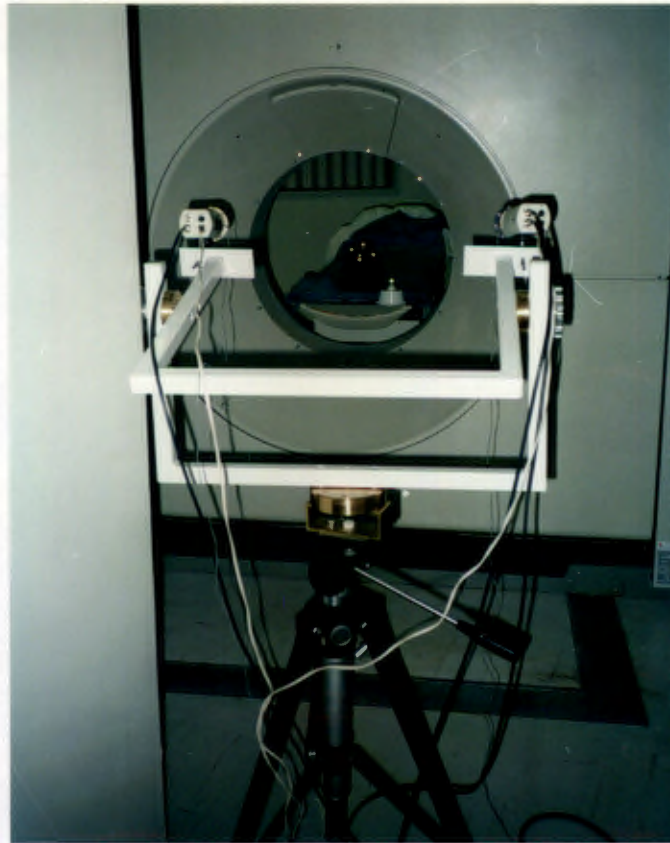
The stereophotogrammetric system in conjunction with the CT scan system
